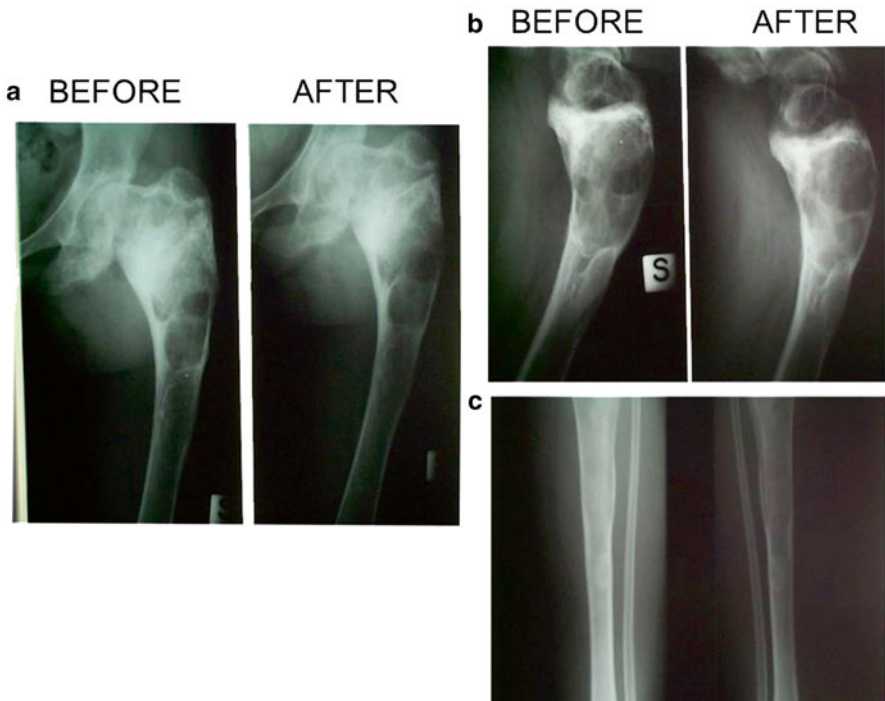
(a–c) MRI images of the left lower limb in the same patient before and after pamidronate, showing stabilization of the cystic lesions
